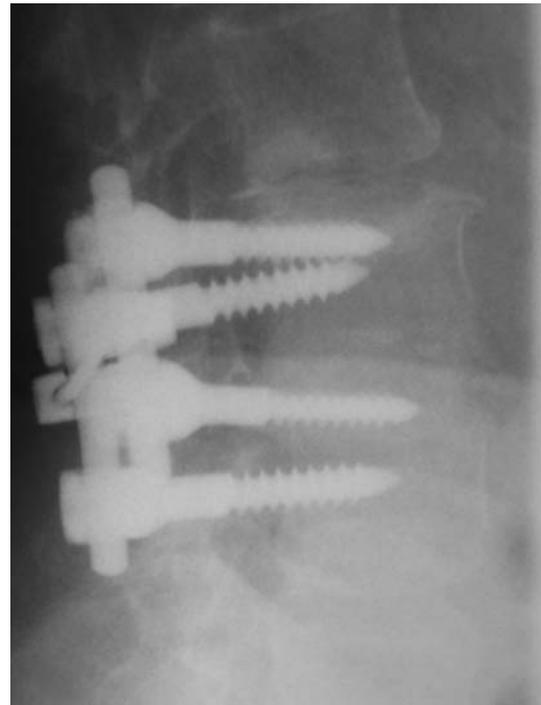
Lateral roentgenogram of the patient of Figs. 10 and 11, 34 months postoperatively showing collapse of this disc. No interspinous implant was inserted at the L2/L3 segment. This patient was revised because of intractable pain 38 months postoperatively
